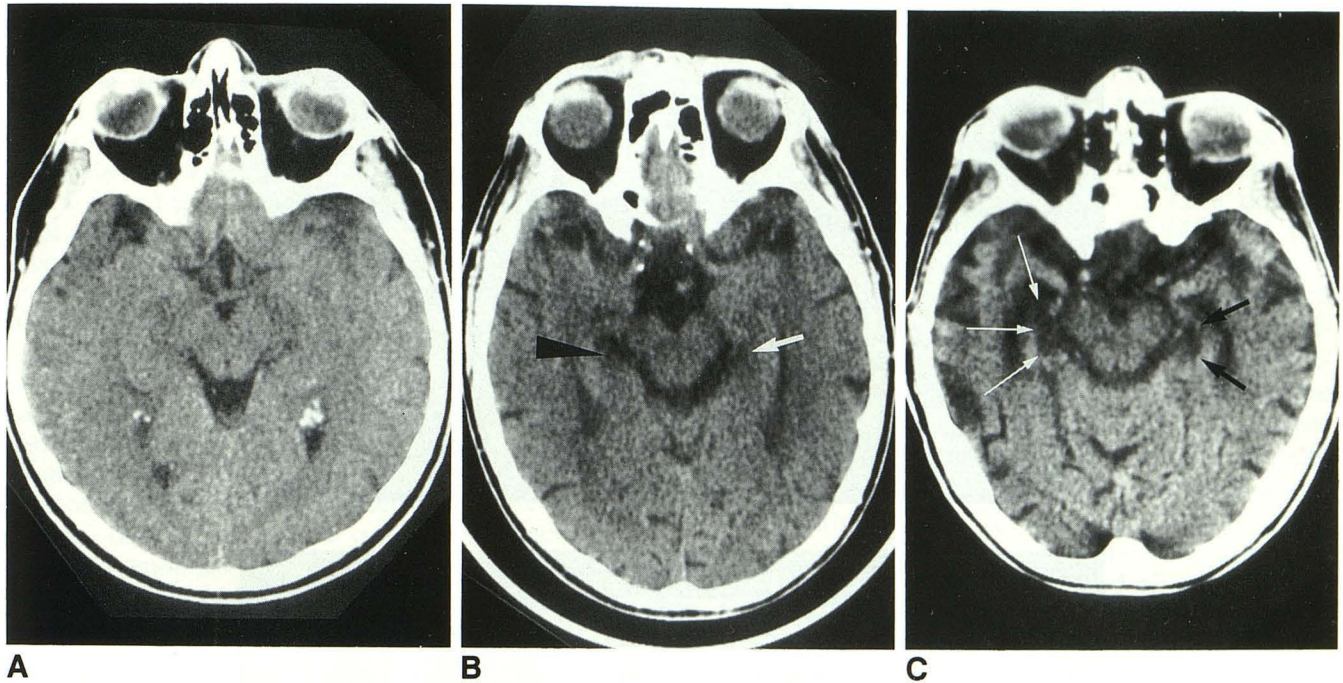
Negative-angulation axial CT views depicting three examples of the HCSF ratings.
